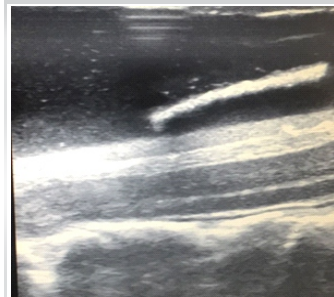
Intra op ultrasound showing good decompression of cord following laminectomy
